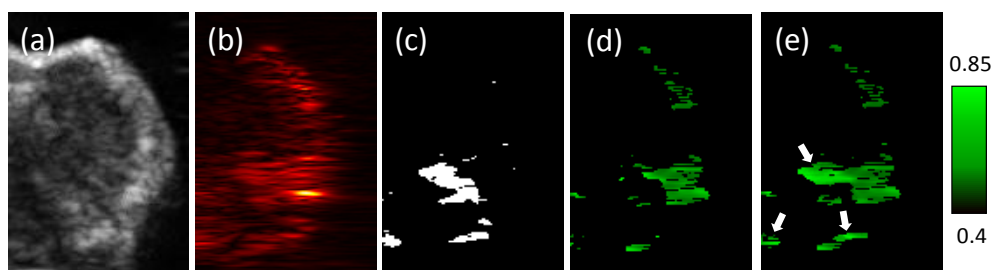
Comparison between linear least square (LLS) and minimum mean square error (MMSE) methods. Ultrasound image (a) was used for the skin-tissue segmentation. The fluence compensated photoacoustic image (b) at 800 nm is shown as a reference. Spectral analysis based on LLS method can produce negative concentrations (c) of optical absorbers due to imperfect fluence compensations, noisy measurements, etc. The regions producing a negative NP concentration by LLS method get removed from the NP image. (d). However, the developed MMSE method can reliably reconstruct spatial distribution and concentration of NP – white arrows in panel (e) indicate locations where NP concentrations were recovered using MMSE method.
